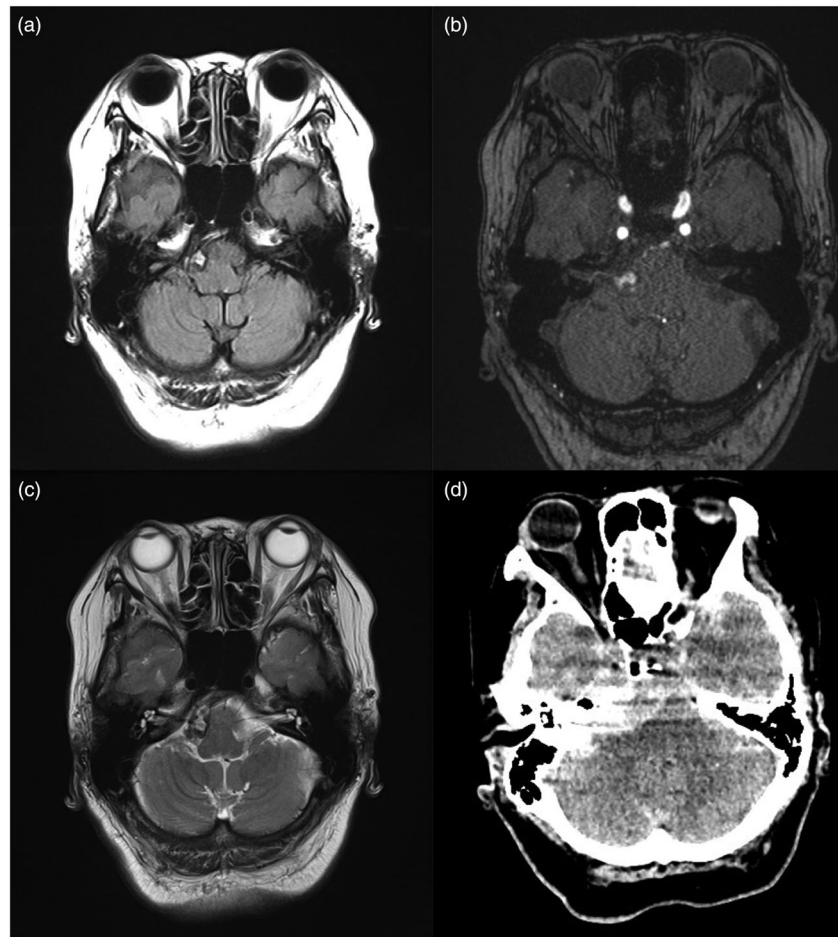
Axial fluid attenuated inversion recovery imaging (a), magnetic resonance angiography source imaging (b), and T2-weighted imaging (c) show a small, 1-mm mass near the CPA attached to the pons. d CT shows massive SAH.
